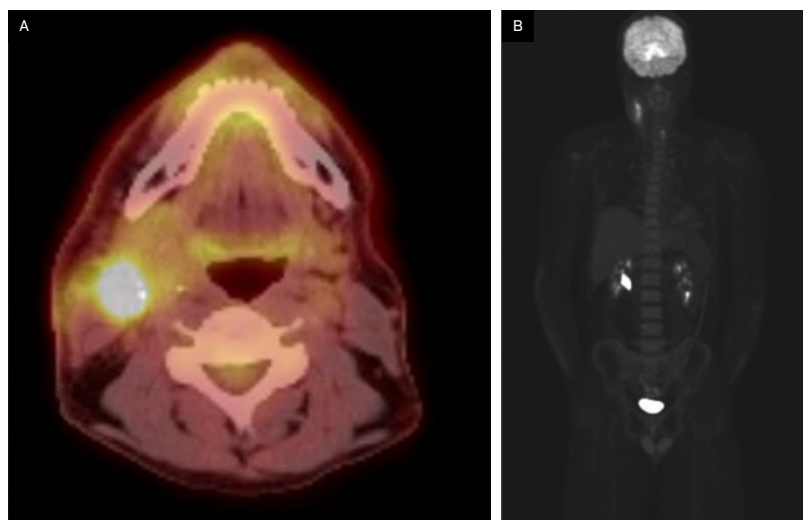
Preoperative F-18 fluorodeoxyglucose (FDG) PET-CT demonstrating FDG-avid lesions.
